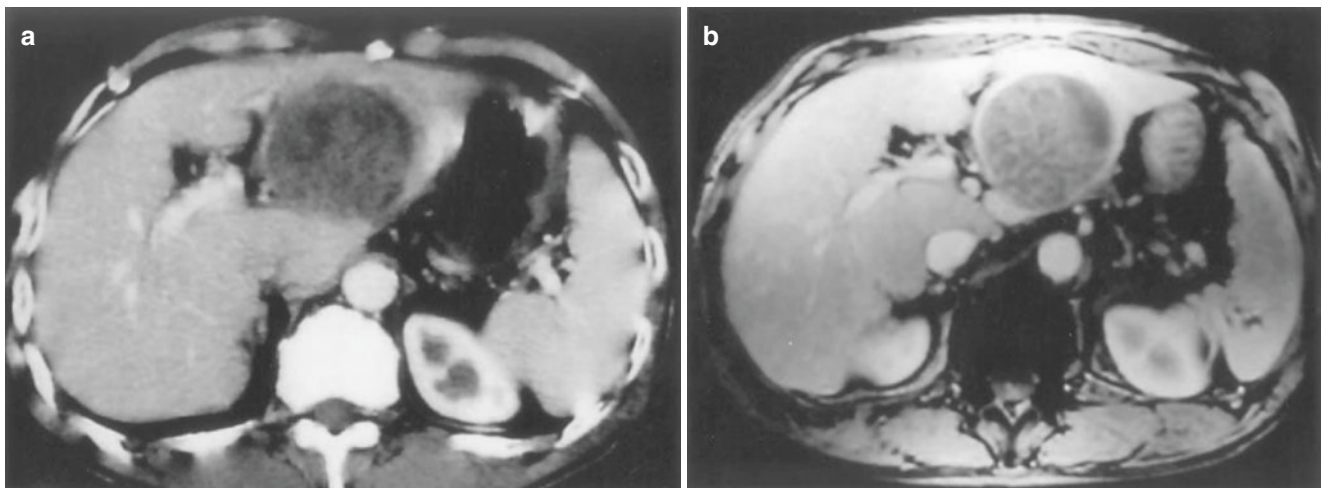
Cystadenocarcinoma; CT images. CT in the early phase shows a low-density area in S4. There are arterial vessels in the tumor, and it is surrounded by arteries (a). CT in the late phase reveals low or heterogeneous density in the tumor, and there is a low-density area on edge (b)
